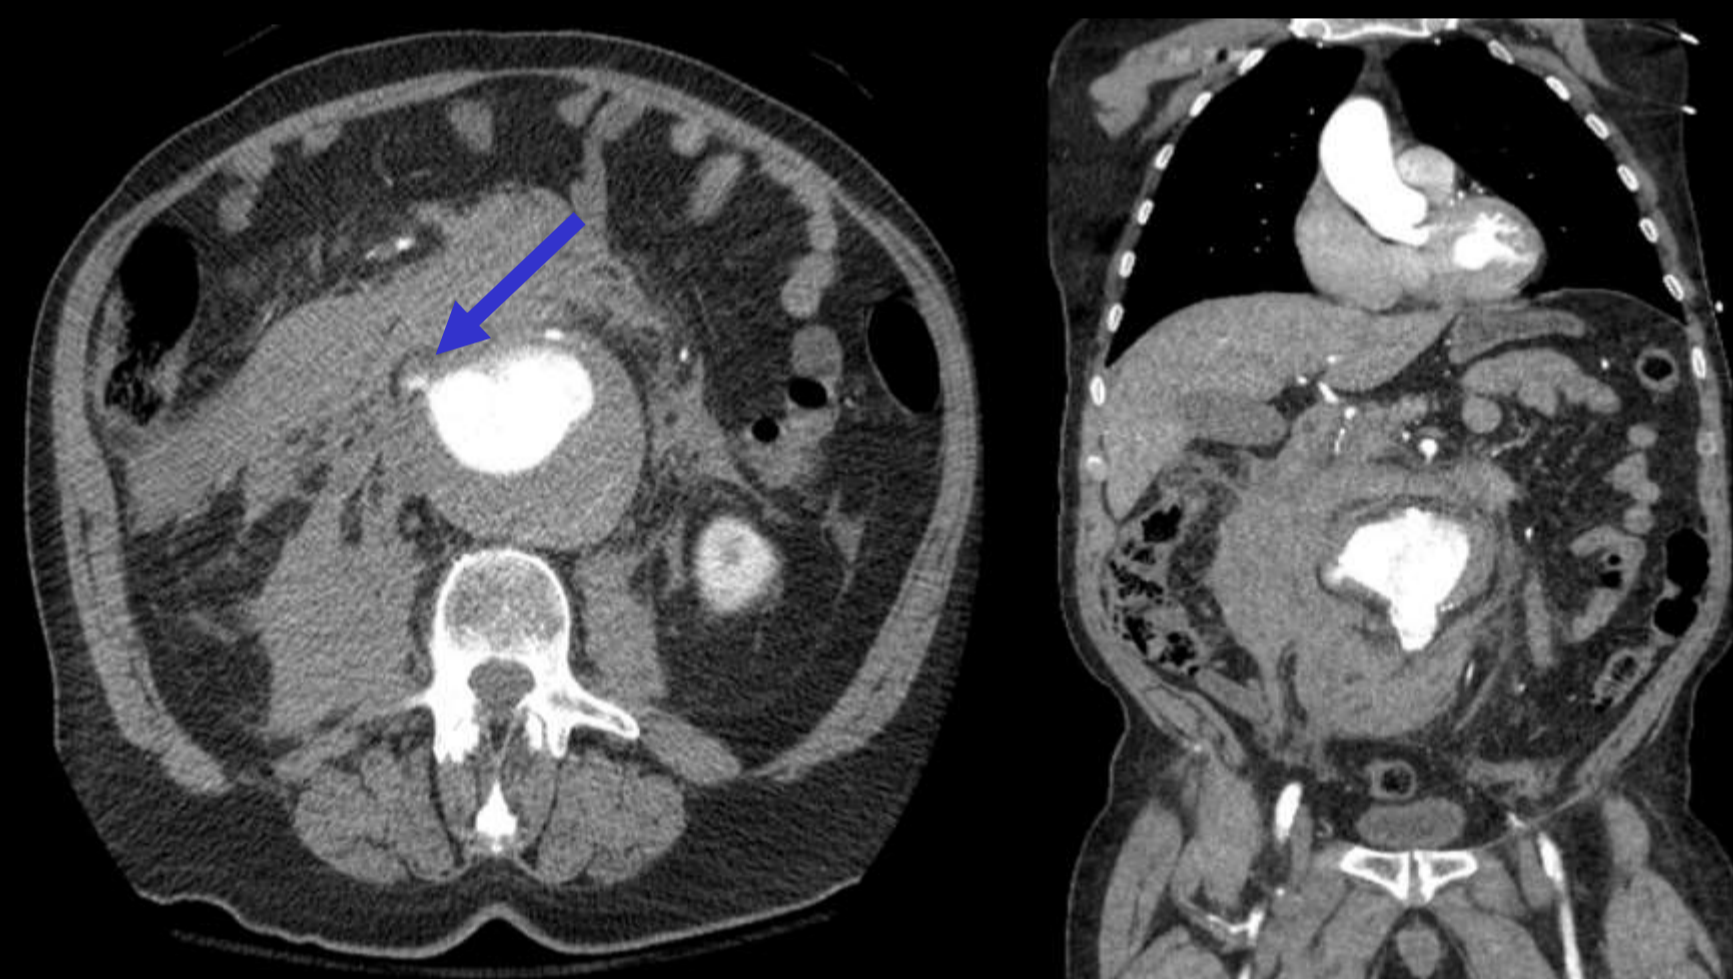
CTA showing a ruptured infra-renal aortic aneurysm
